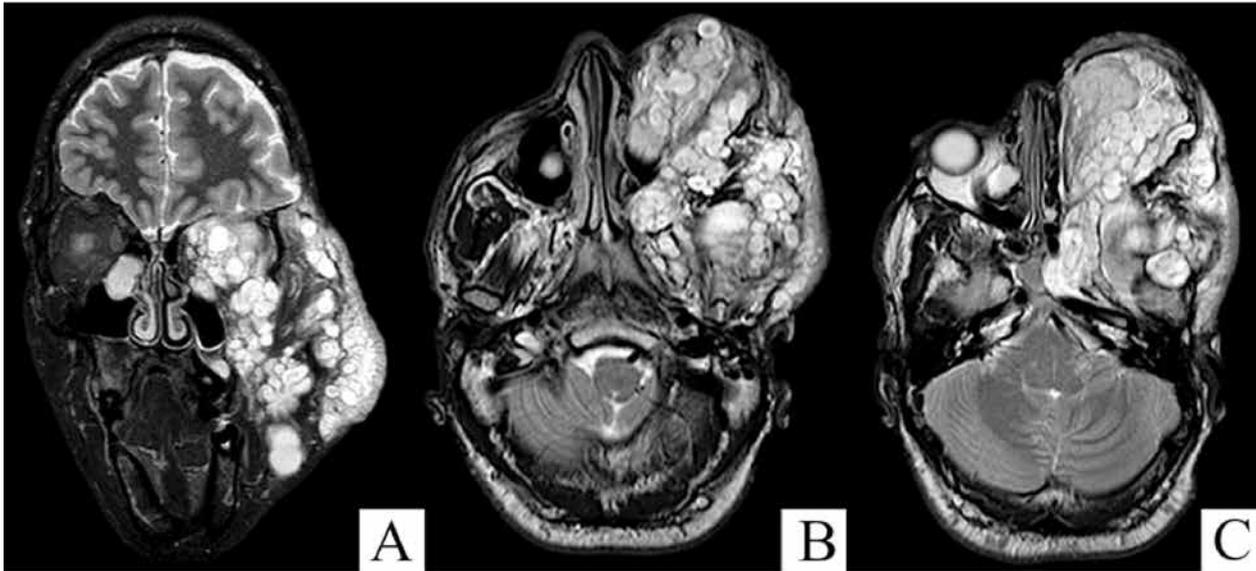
(A) Coronal short-T₁ Inversion Recovery (STIR) and (B,C) axial T₂W MRI images
